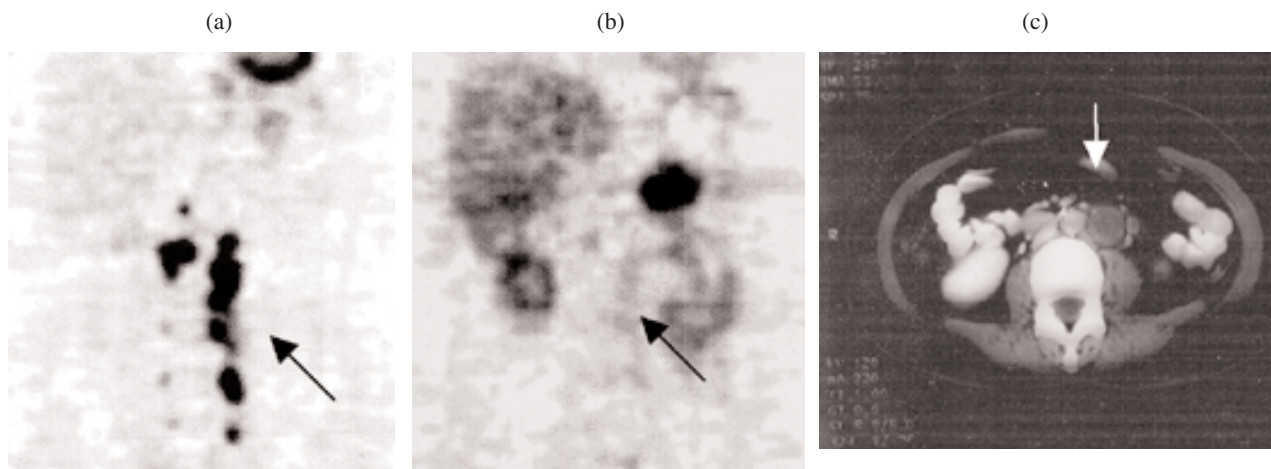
Patient 3 (a case of MMMT with disseminated metastasis): (a) whole body FDG-PET showed paraaortic lymph node metastasis (black arrows, coronal view) (b) not seen in 11C-acetate PET (coronal view) (c) abdominal CT did not show this metastasis (white arrows, transaxial view).
